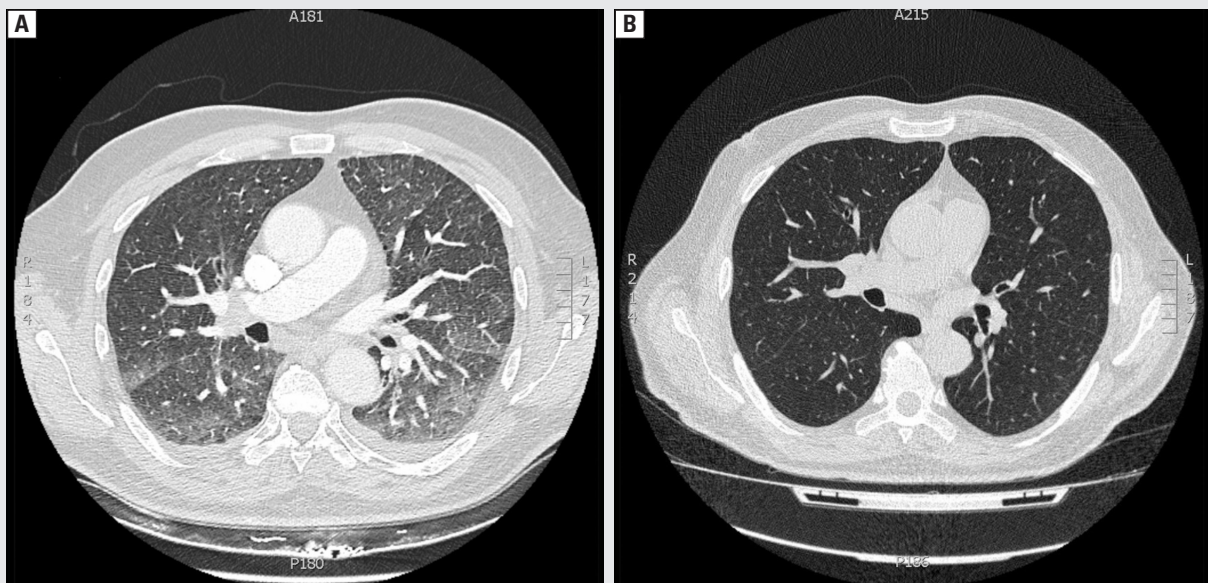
The chest computed tomography (CT) is indicative of lung micronodular lesions (0.5–1 mm) accompanied by oedematous changes. Small pleural effusion in the both pleural cavities can be seen. Bilaterally, particularly in the dorsal segments of the lungs, alveolar consolidation and signs of septal thickening are present. B. In comparison to the previous chest CT, after 2 months of treatment, there has been complete resolution of fluid in the pleural cavities. Also noticeable is a nearly complete resolution of lung micronodules with only few up to 0.5 mm in diameter still present
